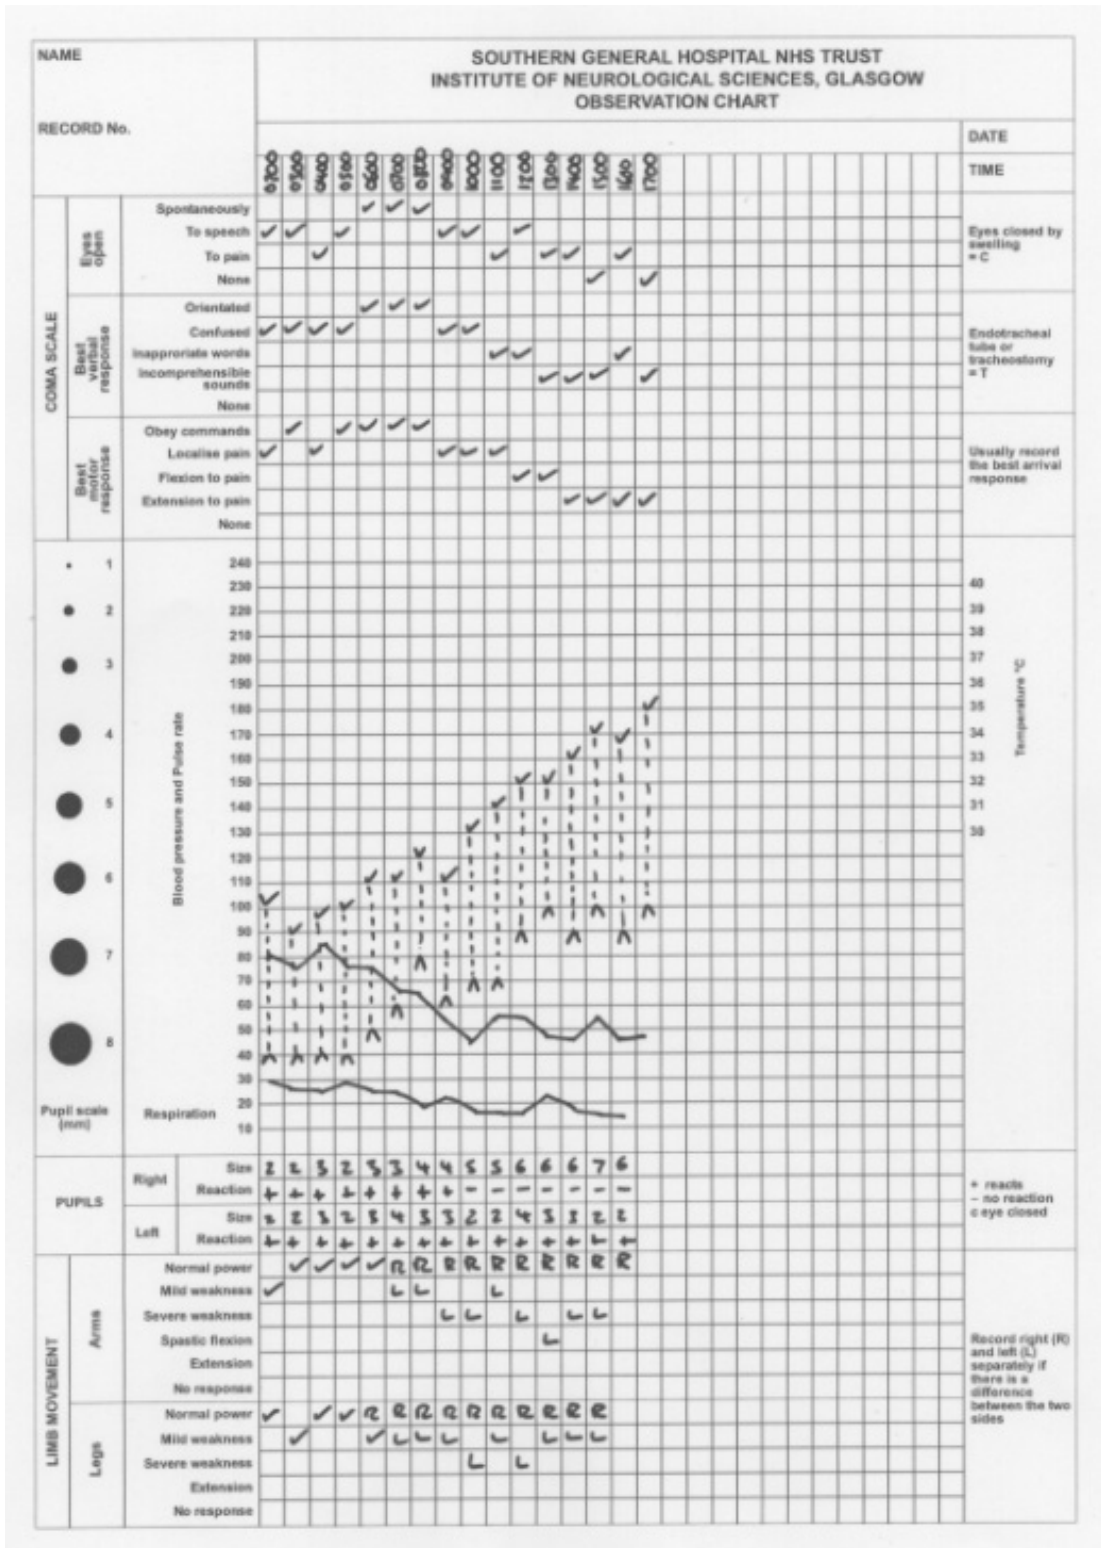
Head injury chart and CT scan appearances from a patient with an extradural haematoma
